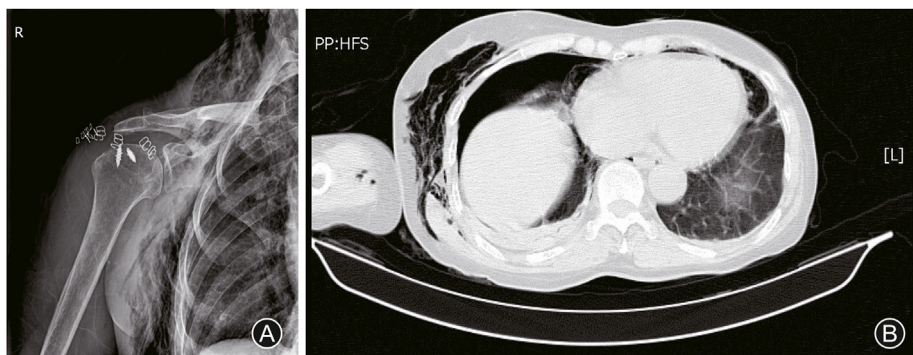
A 66-year-old female suffered from irreparable massive rotator cuff tear and underwent shoulder superior capsular reconstruction in the arthroscopic. (A) Subcutaneous emphysema after the arthroscopic shoulder superior capsular reconstruction surgery; (B) Slight pneumothorax and subcutaneous emphysema were observed through thoracic CT scans.
